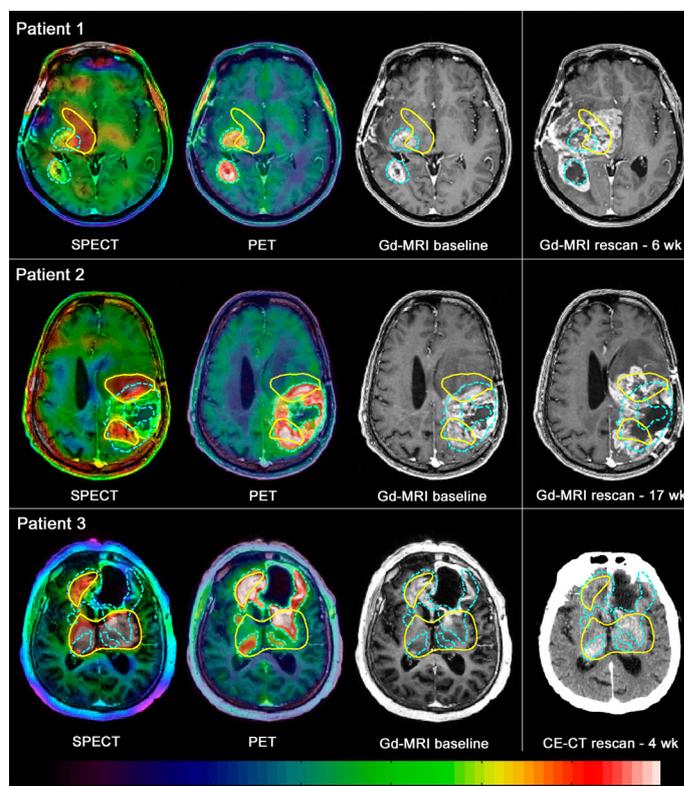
Corresponding (A) [¹²³I]CLINDE-SPECT (demonstrating activated microglia and probably also glioblastoma cells), (B) [¹⁸F]FET-PET (demonstrating amino acid uptake) and (C) structural imaging with contrast enhancement in three patients with advanced glioblastoma multiforme (GBM). Figure from [25], Copyright © 2015 American Academy of Neurology.
